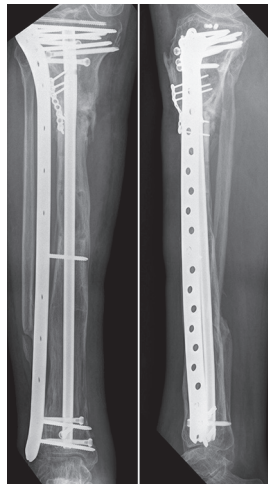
Final A/P and lateral tibial radiographs 16 months after definitive fixation demonstrating union of the docking site and maturation of the regenerate
